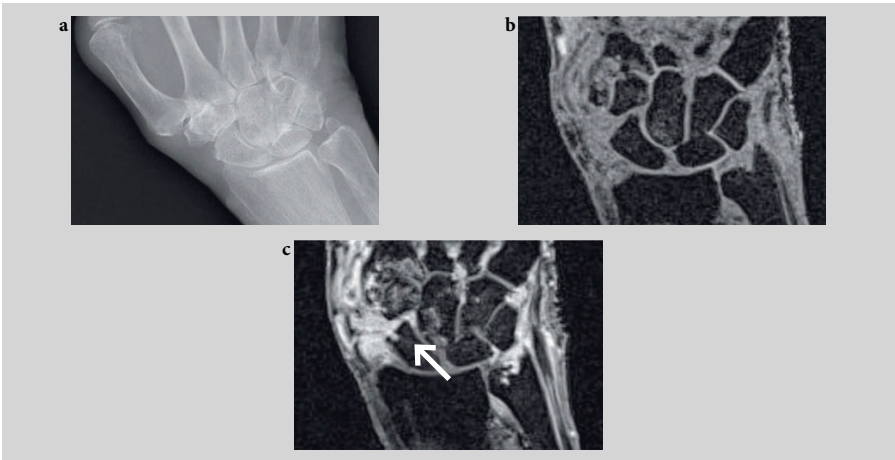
Magnetic resonance imaging in early rheumatoid arthritis. In this patient with early rheumatoid arthritis (RA), although the scaphoid erosion is not seen on the conventional radiograph of the (a) wrist and hand or (b) the precontrast MRI image, it is visualized on the (c) post-contrast MRI image. Synovitis and bone marrow edema are other findings on MRI and indications of soft tissue involvement in early RA. Reproduced with permission from University of Leeds, UK.
